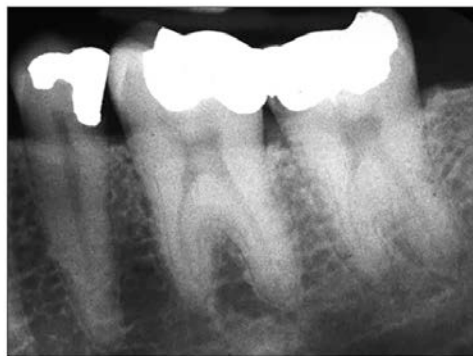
Periapical radiograph of mesotaurodont teeth #18 and #19.
